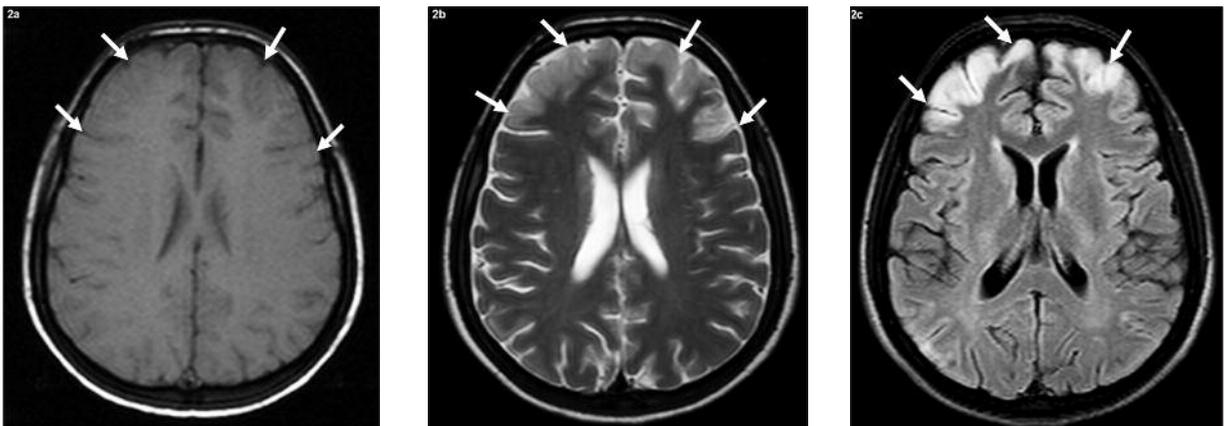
On the 6th day, we observed subacute infarcts [arrows] on [a] T1-weighted, [b] T2-weighted and [c] FLAIR sequence images of the cortical and subcortical areas, slightly hypointense on T1-weighted images and hyperintense on T2-weighted images.
